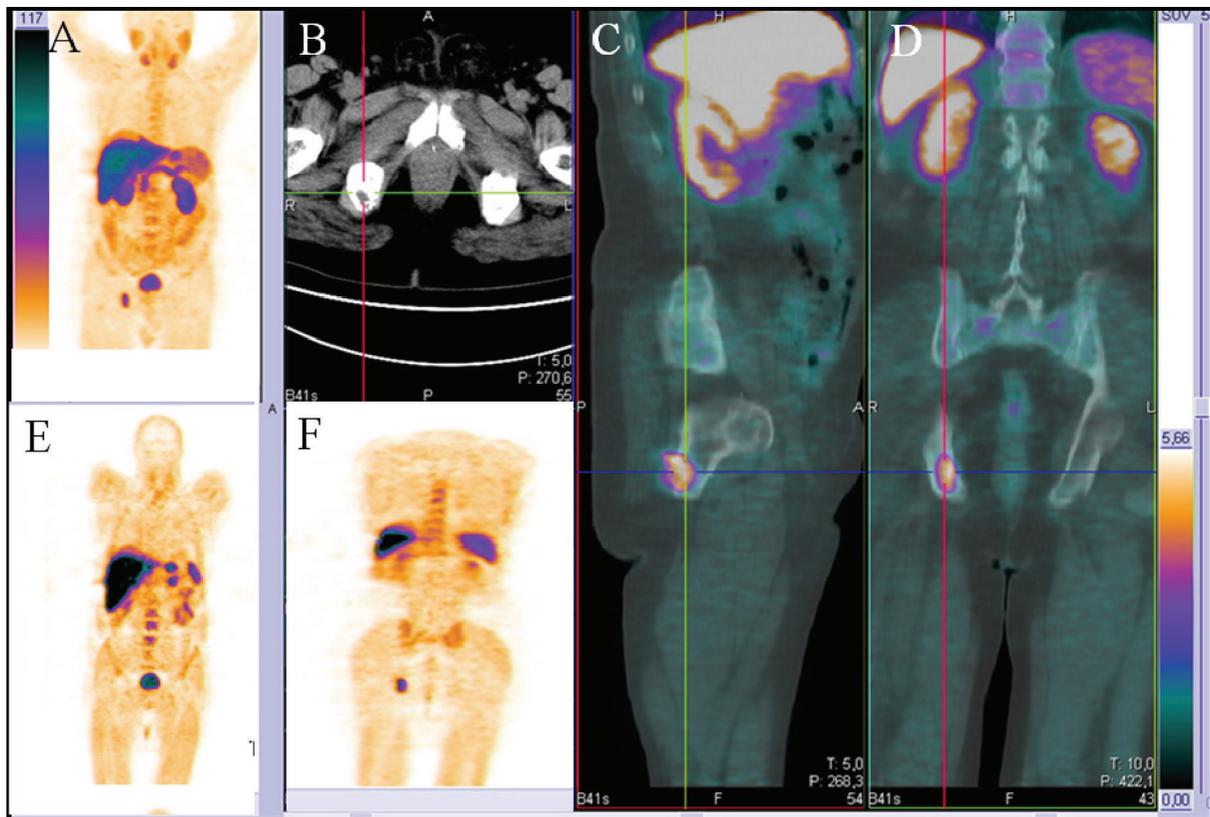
Ch-PET/CT images of a 73-year-old patient with biochemical failure (PSA serum value 2.1 ng/mL) after radical prostatectomy for prostate cancer with a metastatic lesion at the right ischiopubic branch. (A, E, and F) Whole body coronal PET images showing an uptake of the radiotracer at the level of the right ischiopubic branch. No uptake at the lymph node stations and at the level of the postprostatectomy bed was found. (B) Axial morphological CT image of the pelvis displaying a hypodense nodular lesion at the level of the right ischiopubic branch. (C) Sagittal and (E) coronal fused PET-CT images showing the uptake of the radiotracer at the level of the right ischiopubic branch.
